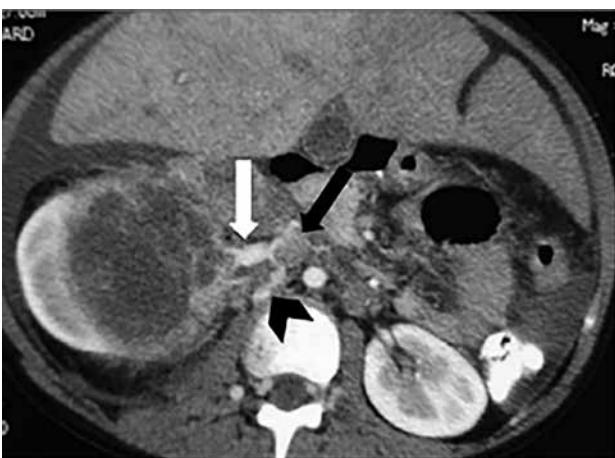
A heterogeneous hypoattenuated mass (white arrow), seen on axial contrast-enhanced CT, suggests a neuroblastoma. Thrombosis of the inferior vena cava (black arrow) is also displayed. It drains into a collateral vein (arrowhead). (Mehta SV, Lim-Dunham JE. Ultrasonographic appearance of pediatric abdominal neuroblastoma with inferior vena cava extension. *J Ultrasound Med* 2003; 22: 1091-1095)
